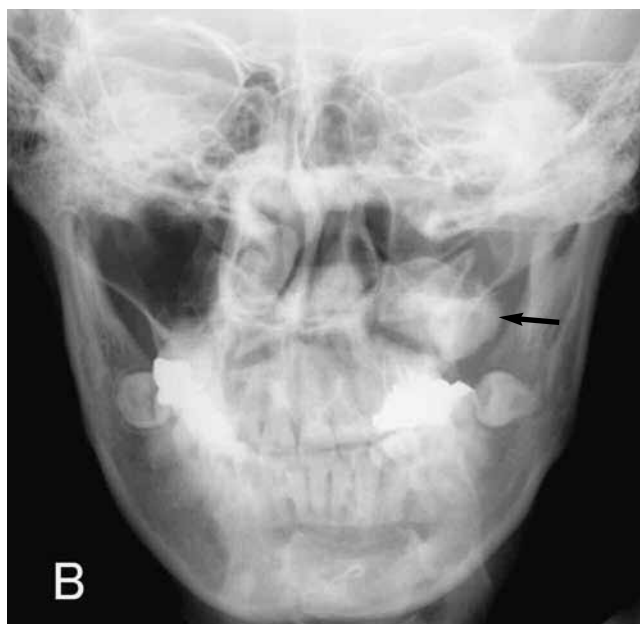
A. Panoramic radiograph shows a unilocular radiolucent lesion in the left maxilla with an impacted tooth (arrow) and some radiopacities. B. PA shows a unilocular radiopaque lesion in the left maxilla (arrow). The lesion is expansive.
